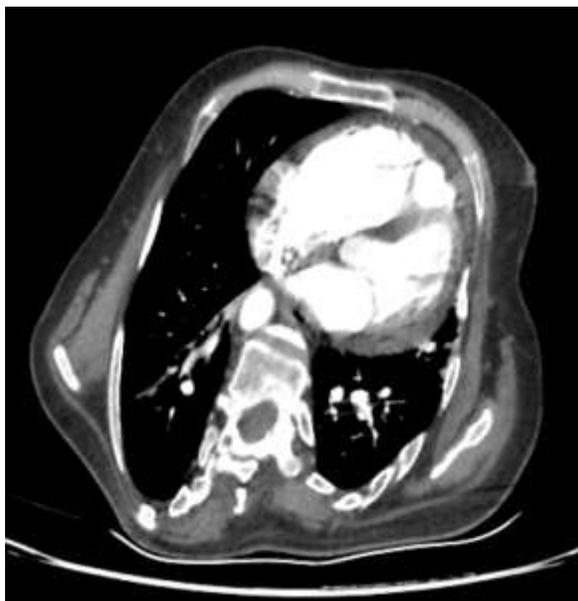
CT Chest showing the scoliotic spine to cause compression over the oesophagus.
